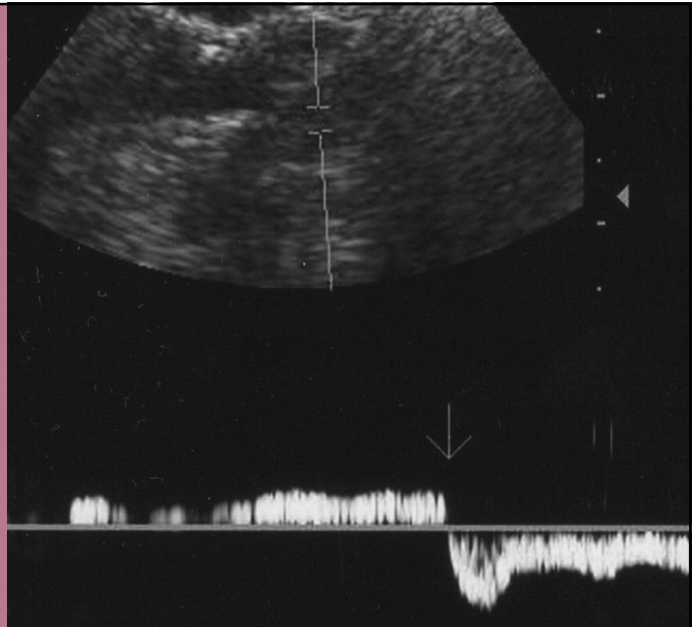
Spectral Doppler of dilated ovarian venous plexus with reversal of flow on Valsalva's maneuver that correlates with reflux on selective ovarian venography (not shown).<sup>10</sup>
